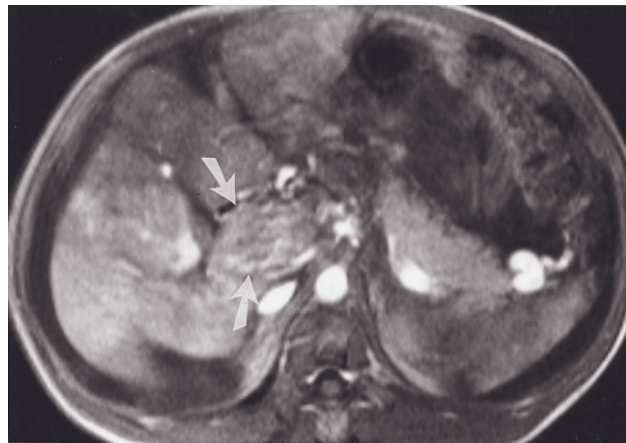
(Continued) Coronal T2-weighted SS-ETSE (*m*), echo-train STIR (*n*), and immediate postgadolinium SGE (*o*) images in a third patient. There is expansion of the right and left portal veins consistent with tumor thrombus. Heterogeneous tumor is identified in segment 4.
